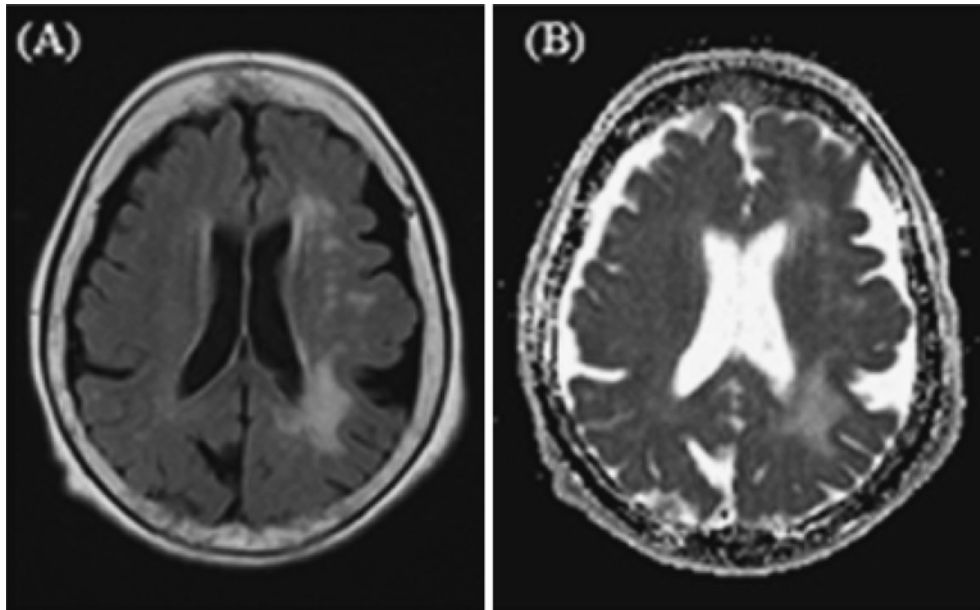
Brain magnetic resonance images.
